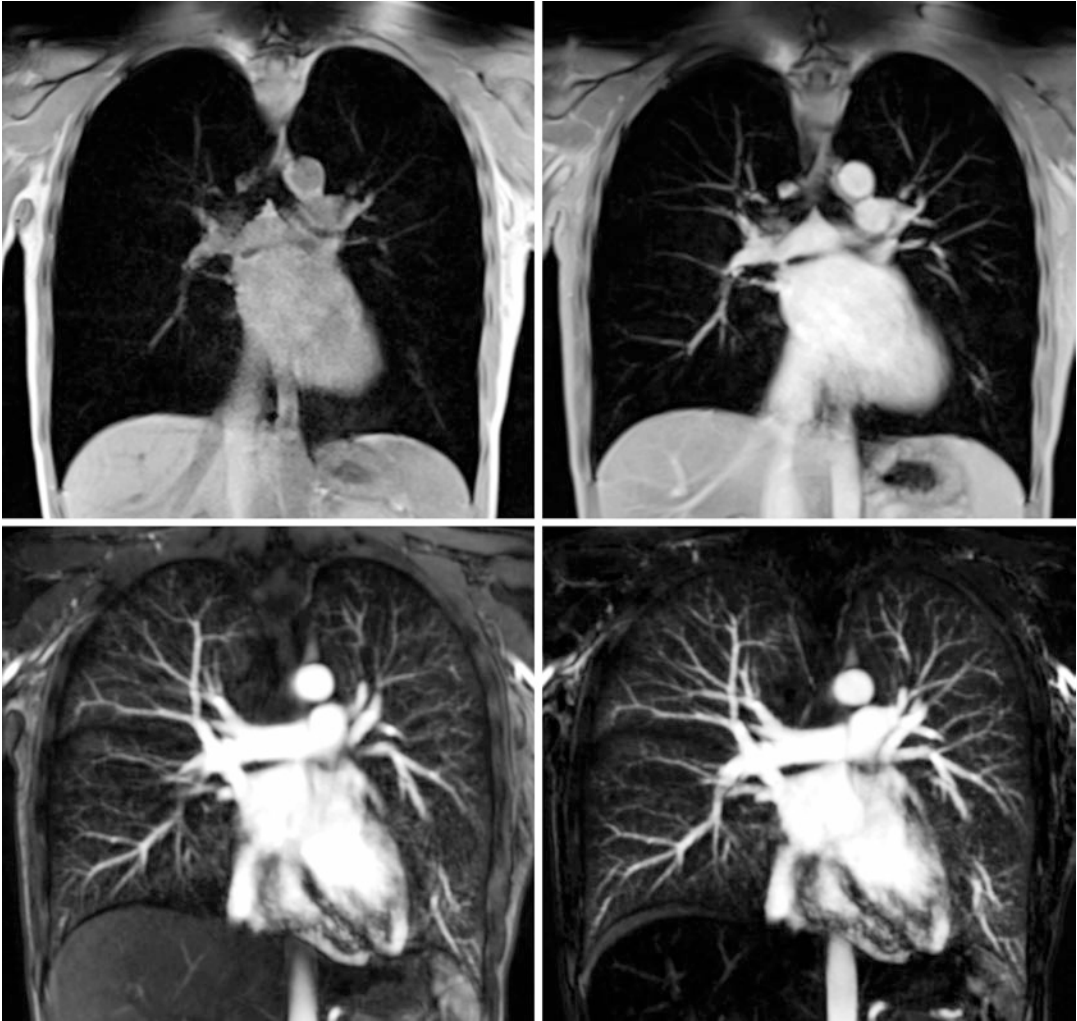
Lung MRI at 3 T, same subject as in Fig. 8: T1-weighted volumetric interpolated 3D gradient echo sequence (VIBE, coronal acquisition in breath-hold) pre
